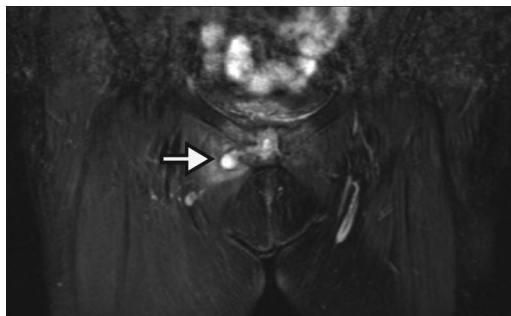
Coronal T2-weighted magnetic resonance image showing signal intensification in the pubic symphysis and right obturator externus muscle with interconnected fluid collections and hypointense peripheral rim.
